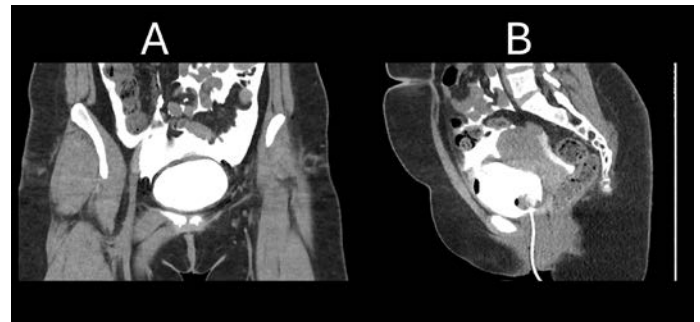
A computed tomography scan of the pelvis showing extravasation of contrast, which is consistent with an intraperitoneal bladder rupture. A: coronal view; B: sagittal view
